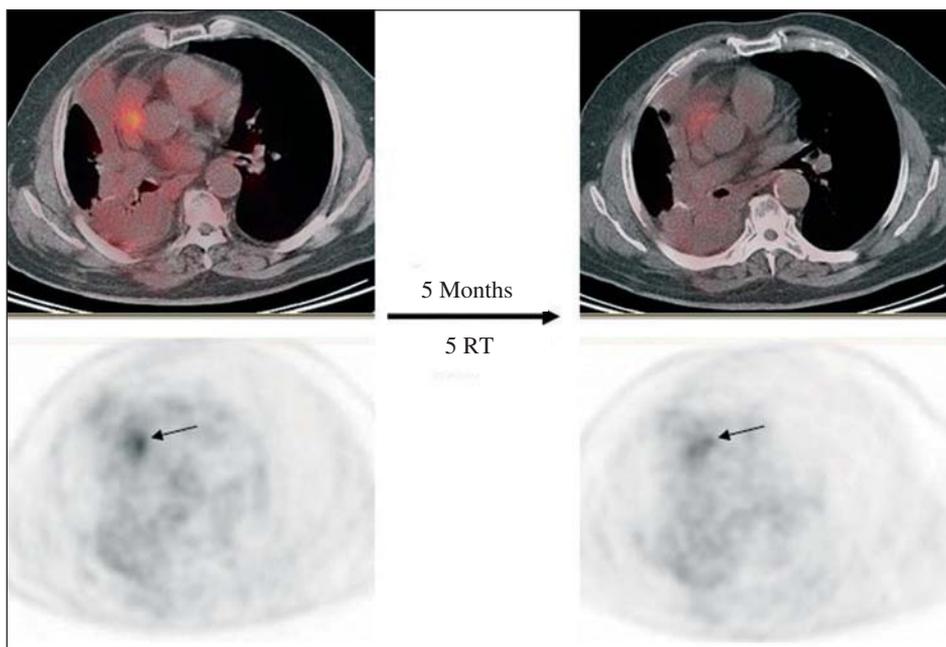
Epidermoid lung carcinoma T4 N0 M0. Neoadjuvant chemotherapy. Evaluation of residual activity after radiotherapy (RT). Possibility of rescue surgery. Positron emission tomography–computed tomography: fluorodeoxyglucose uptake after RT showing post-treatment changes.
